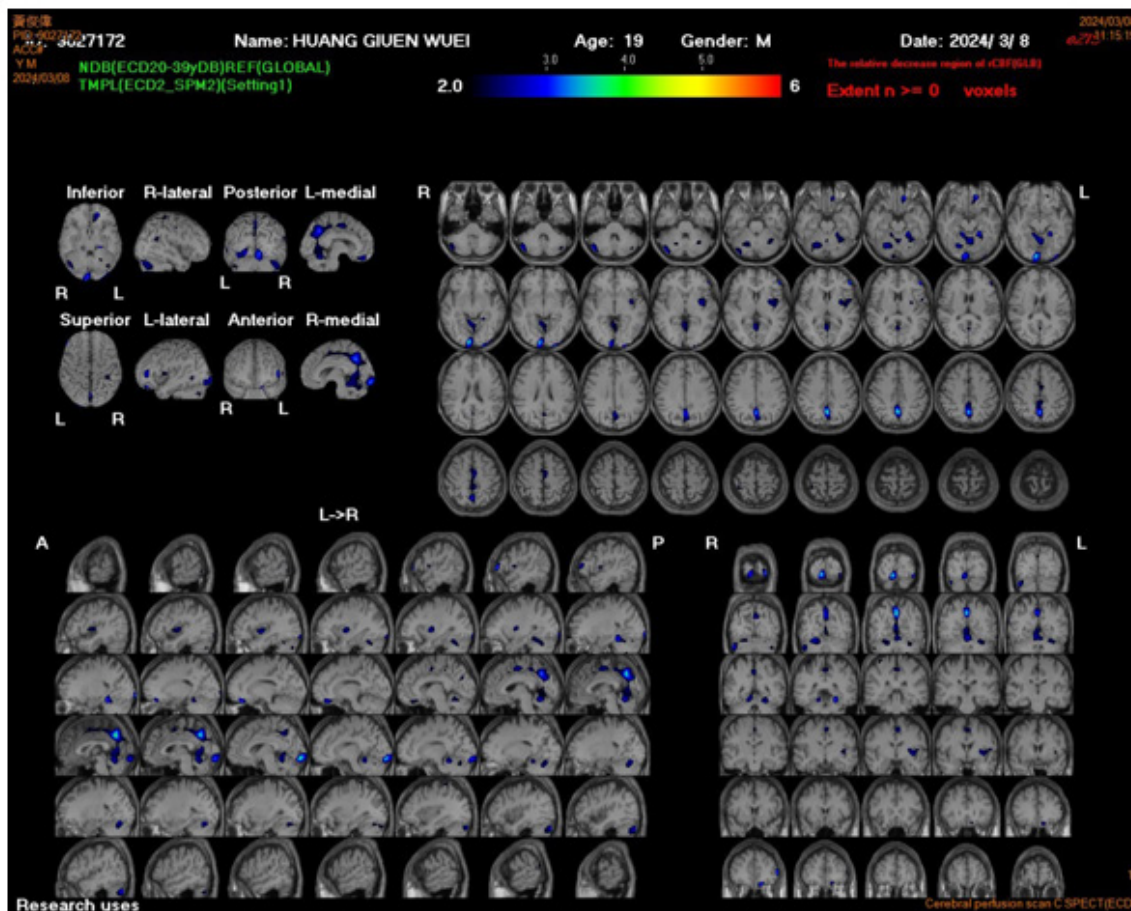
The easy Z-score imaging system (eZIS). A method for automated diagnosis of brain perfusion SPECT, an easy Z-score imaging system (eZIS). Since SPECT exhibits greater variations in image quality among different centers than PET, conversion of SPECT images may be necessary for sharing a normal database. In our case, it shows a low Z-score in the posterior cingulate gyrus with unclear reason.
